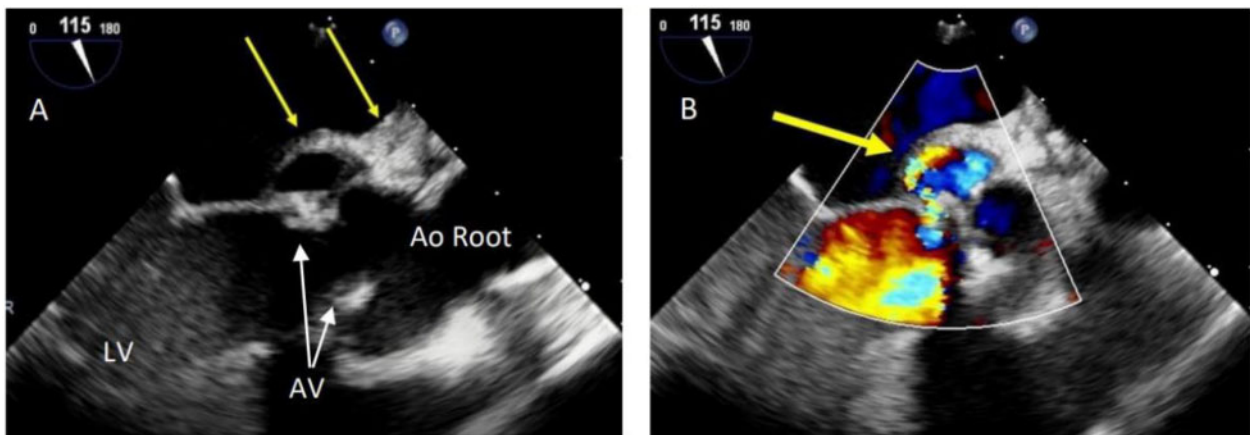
Pre-operative mid-oesophageal long-axis view transoesophageal echocardiogram of the aortic root mycotic/pseudo-aneurysm and abscess (yellow arrows). (A) Without colour Doppler showing an aortic root mycotic aneurysm with an abscess. (B) With colour Doppler showing flow velocities within the aneurysm. There is also an associated mild paravalvular aortic incompetence. Ao Root, aortic root; AV, aortic valve; LV, left ventricle.
